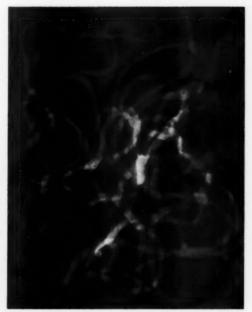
Case I. Radiograph of the tangled mass of worms found in one bowel movement.
